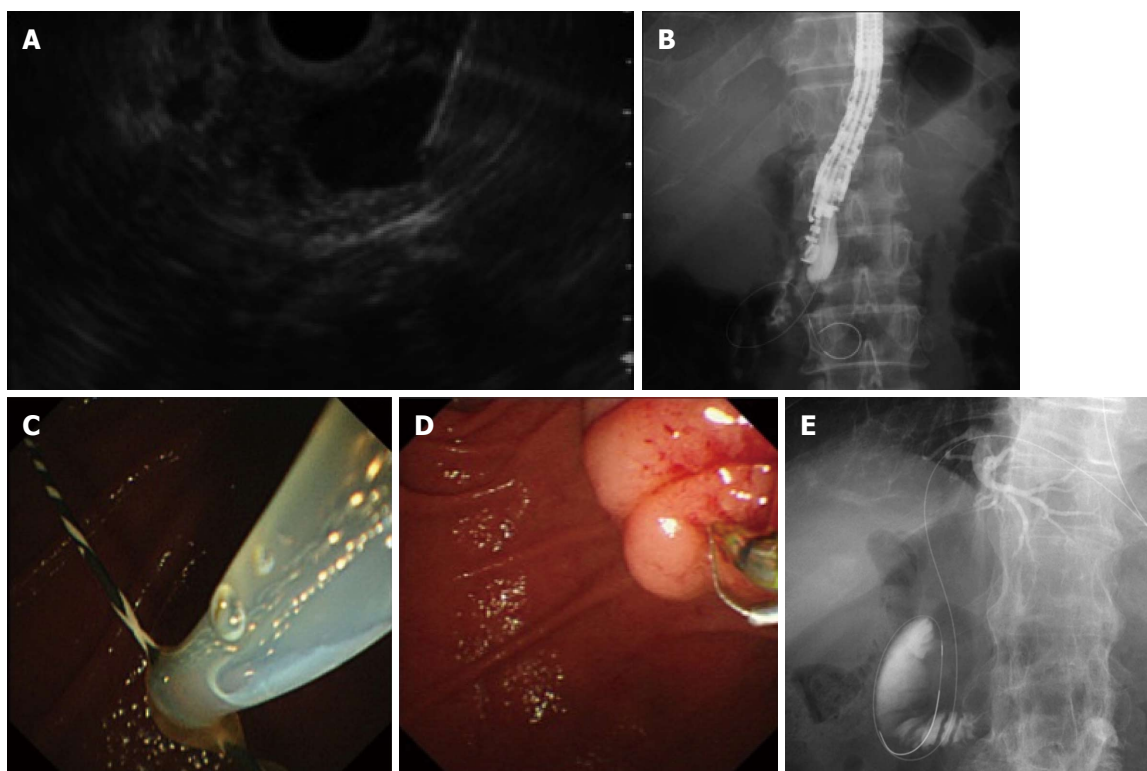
Endoscopic ultrasonography-guided rendezvous procedure. A: Endoscopic ultrasonography showing that extrahepatic bile duct was punctured by the needle; B: Radiography showing the guidewire was passed through the needle into the duodenum across the papilla antegradely. The endoscope was in the short position; C: Following echoendoscope withdrawal, the duodenoscopic view showed that a guidewire passing through the papilla was grasped by the snare; D: After the guidewire was pulled out through the accessory channel of the duodenoscope, a catheter was inserted into the bile duct over the existing guidewire; E: Transhepatic approach. Abdominal radiography shows that a guidewire was placed through the papilla into the duodenum.
